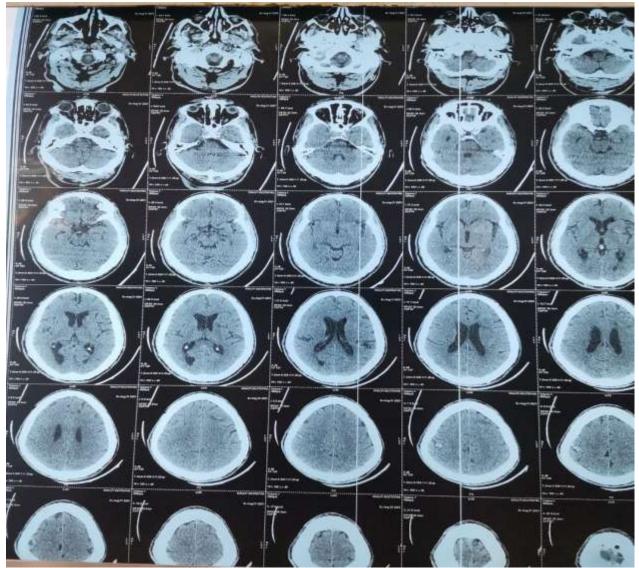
Cerebral CT scan performed after stabilization of the patient.
